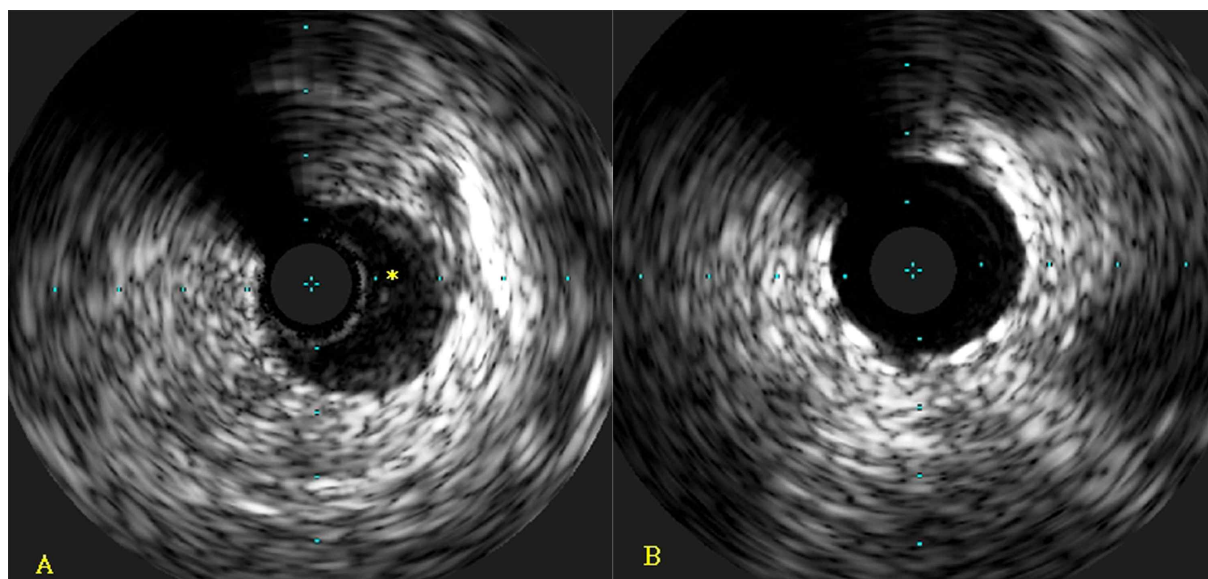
Intimal tear and hematoma(*) of the left anterior descending artery, revealed by intravascular ultrasonography
